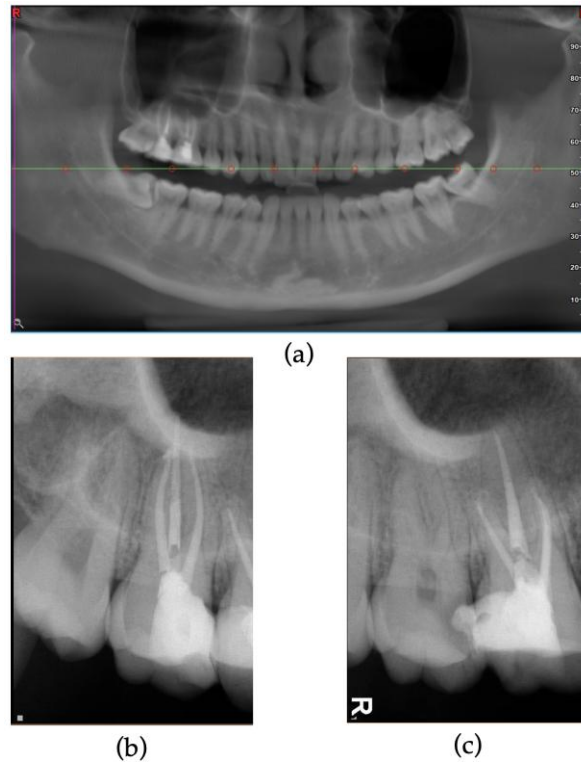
Panoramic (a) and periapical films (b and c) of teeth #16 and #17. Both #16 (c) and #17 (b) had undergone successful root canal treatment.
